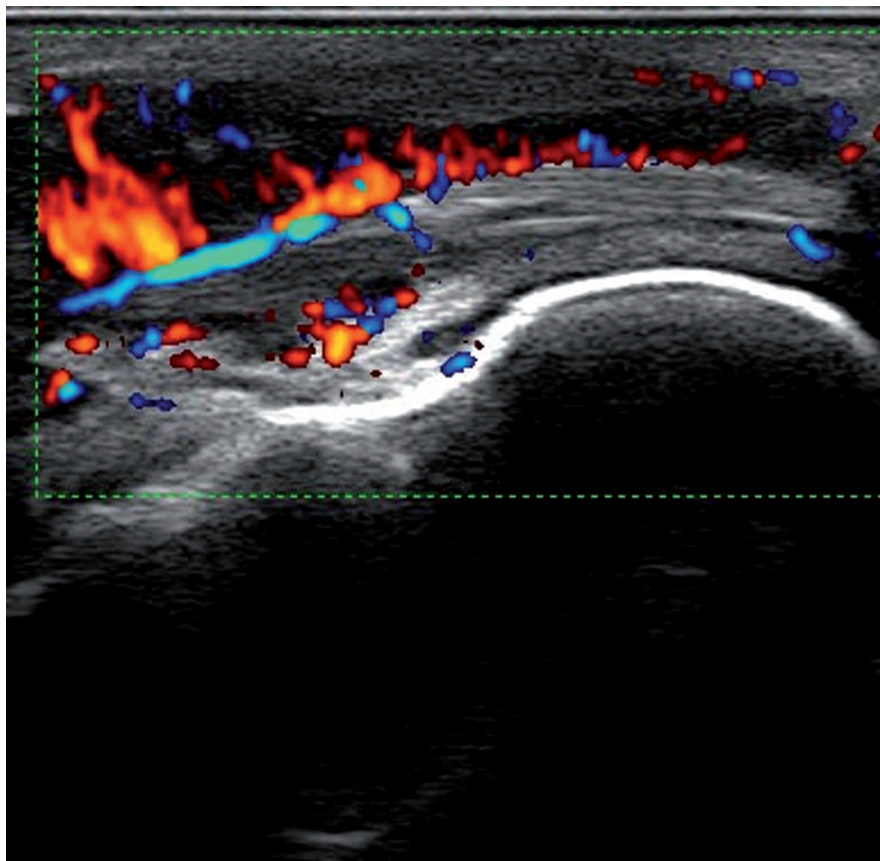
Longitudinal ultrasound image of the tibialis posterior tendon that shows tenosynovitis on B-mode and power Doppler mode (diffuse Doppler signal within the distended synovial sheath).
